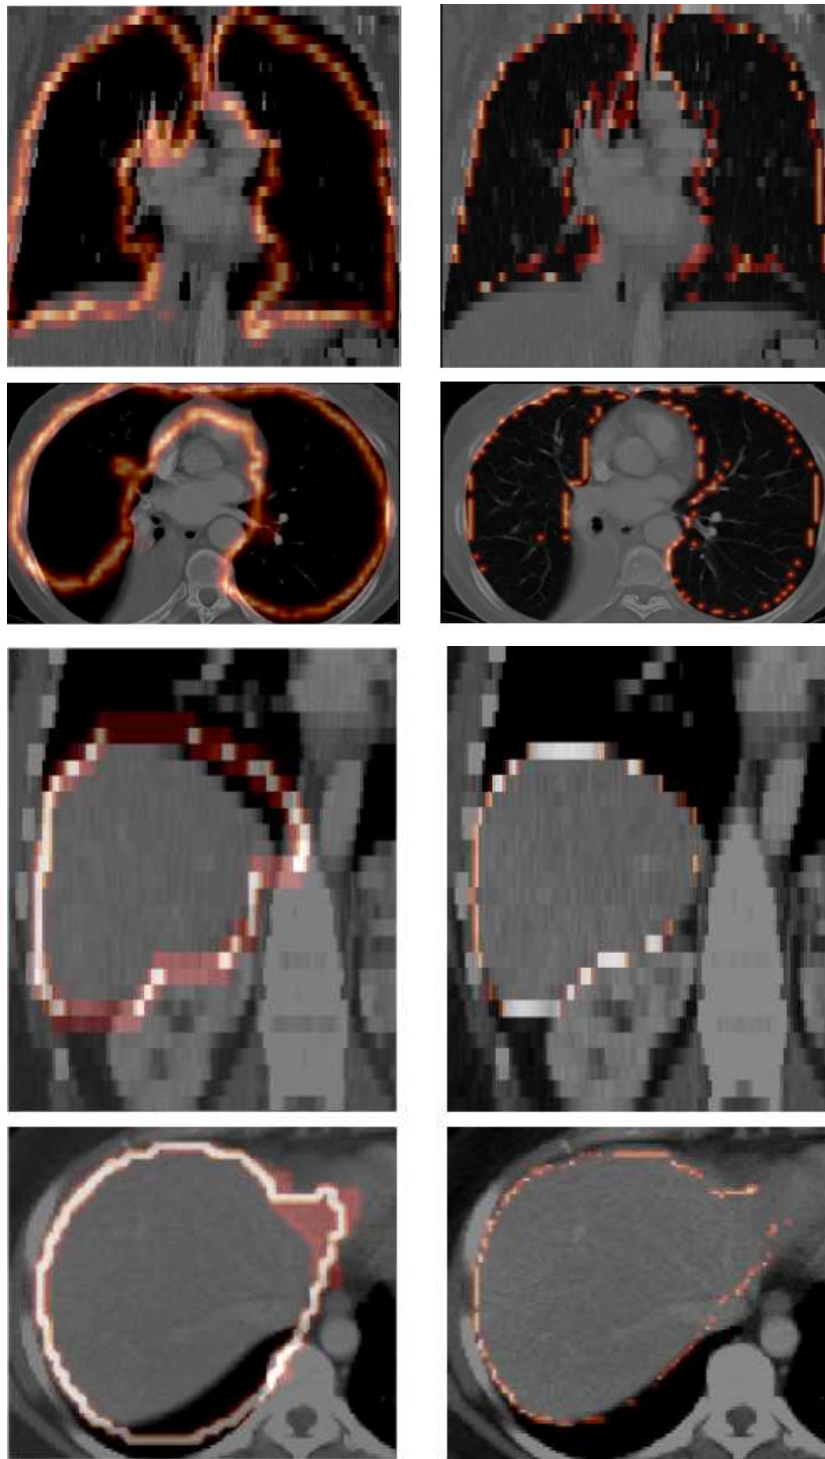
Structure registration results obtained with the ICP-based method. Grey-level coronal and axial CT slices are superimposed on contours (red temperature) of registered PET lungs (top rows) and liver (bottom rows). Left: PET structures registered with a linear transformation. Right: PET structures registered with the ICP-based method.
